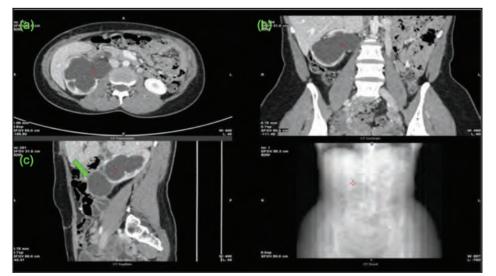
A four-phase renal contrast enhanced CT scan in (a) axial, (b) coronal and (c) sagittal views during the nephrographic phase, which revealed a large cystic lesion (green arrow) arising from the right parapelvic region.
